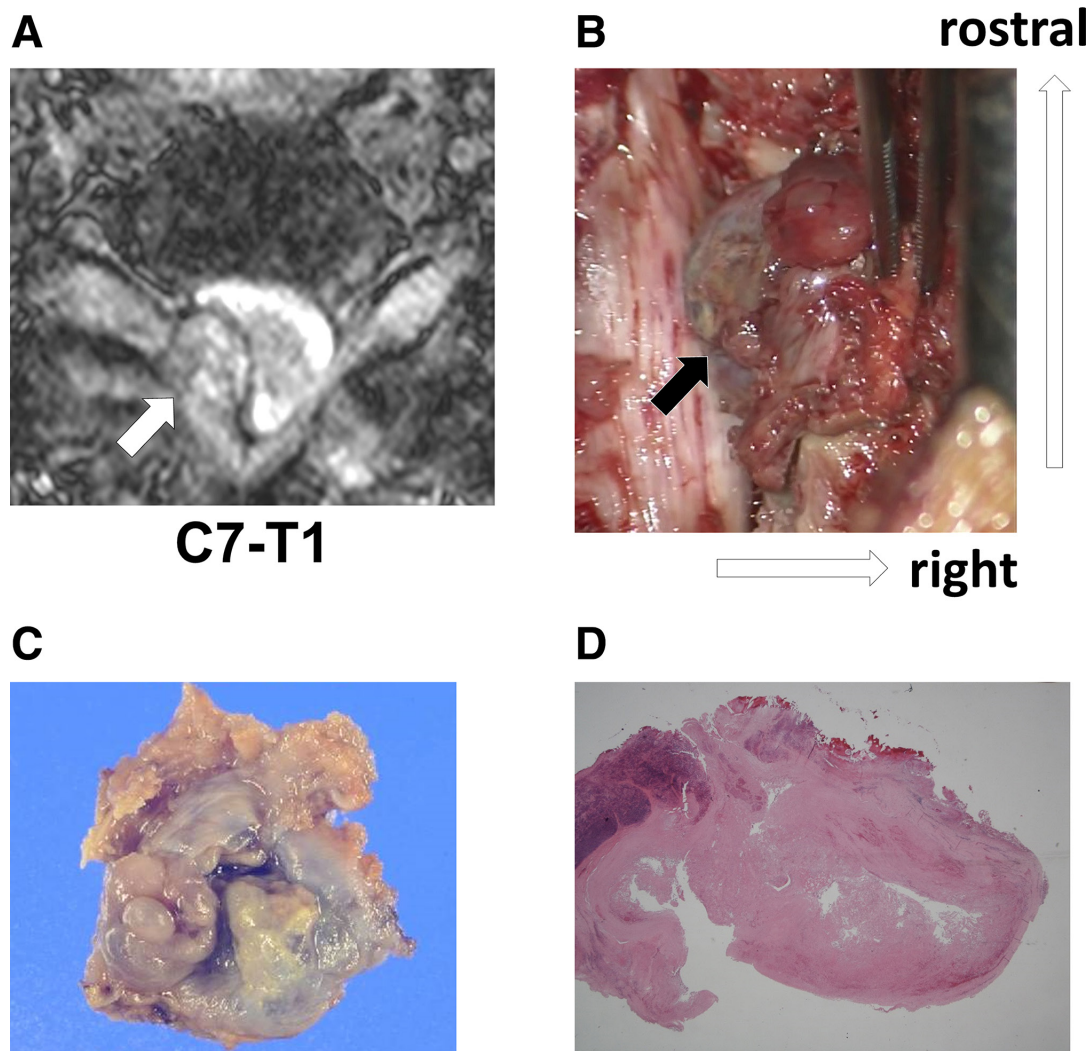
A magnetic resonance image (MRI), an intraoperative photograph, a macrograph, and a pathological image of the resected cyst in Case 2. (A) T2-weighted axial MRI image in C7-T1. The white arrow points to the cyst. (B) An intraoperative photograph. The black arrow points to the cyst in ligamentum flavum. (C) A macrograph of the resected cyst. The color is dark red due to bleeding into the cyst. (D) A pathological image of the resected cyst. A ganglion cyst containing red blood cells and fibrin.
